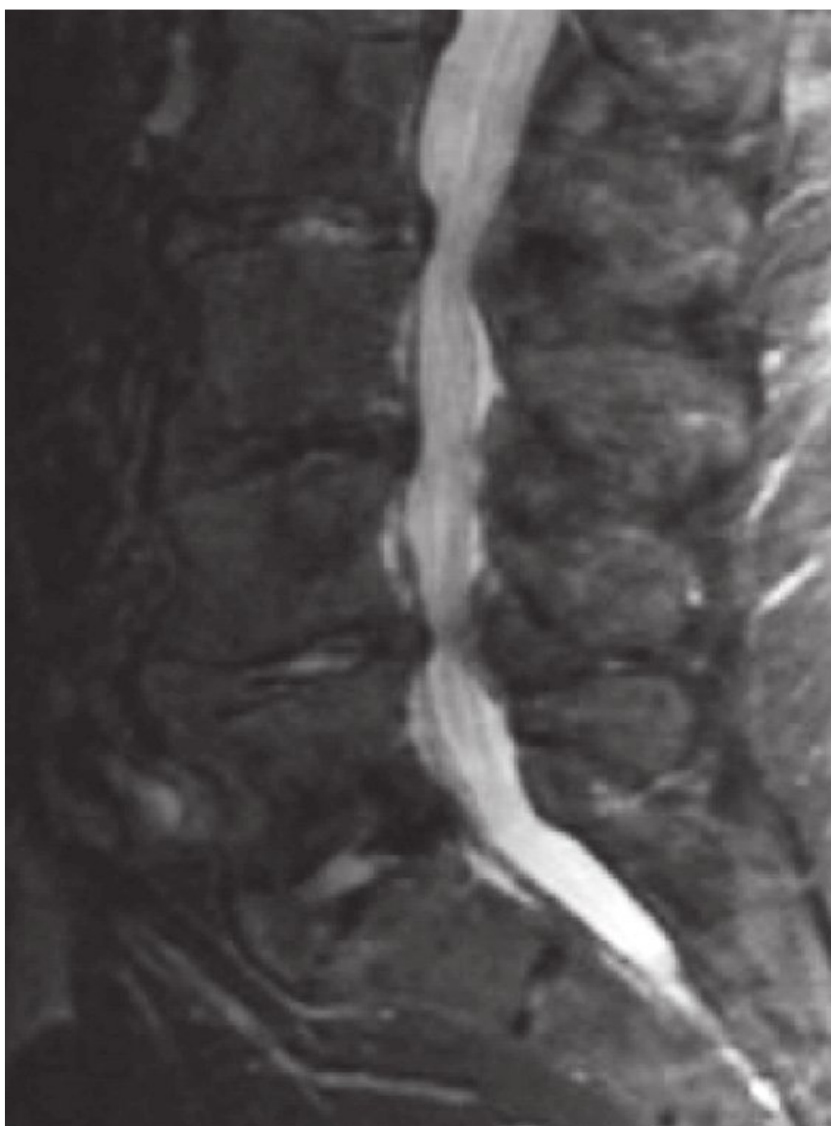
Magnetic resonance imaging demonstrating spinal stenosis secondary to a herniated lumbar disk. (From Imhof H, ed. *Spinal Imaging [Direct Diagnosis in Radiology]*. Stuttgart, Germany: Georg Thieme Verlag; 2008: Fig. 3.35. Reproduced with permission.)
